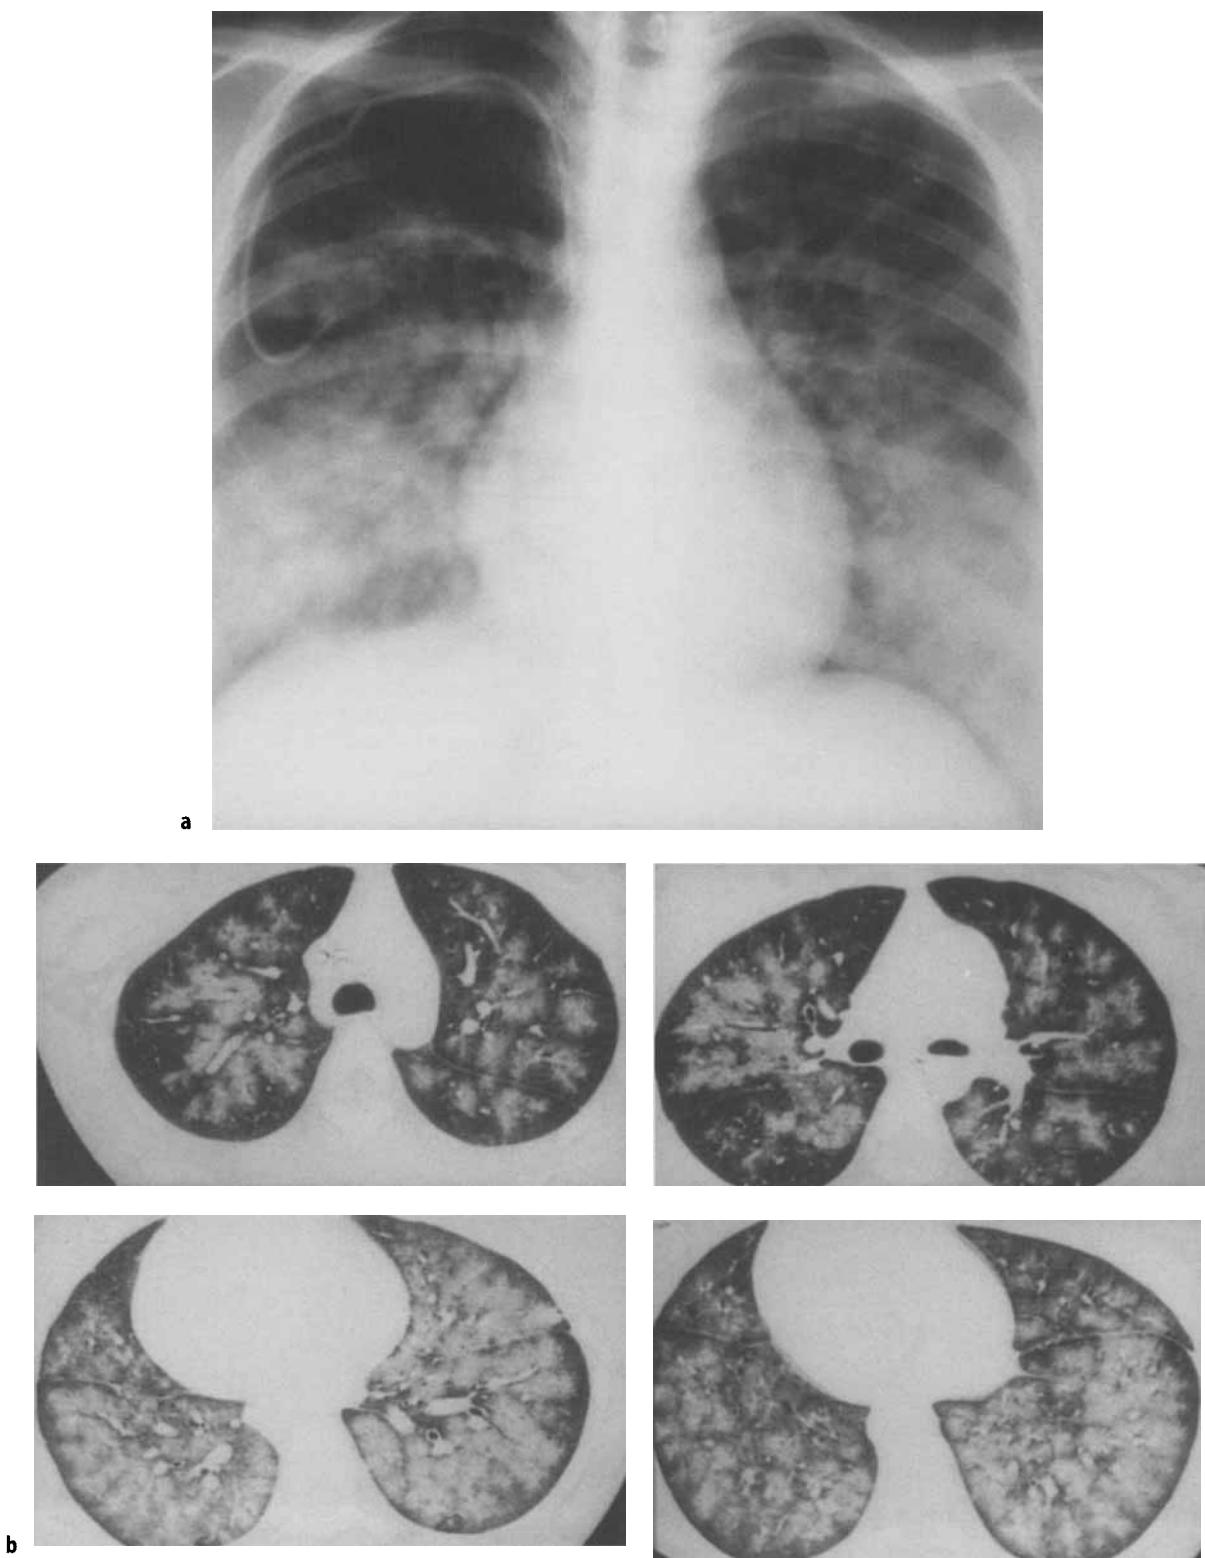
a. Diffuse homogeneous consolidation in the lower lung zones, bilaterally in a patient submitted to bone marrow transplantation, with a c.v.c. in SVC. b. HRCT shows a severe interstitial-alveolar involvement, with consolidation of the alveolar spaces, due to mononucleate cell deposition and air space hemorrhages.
